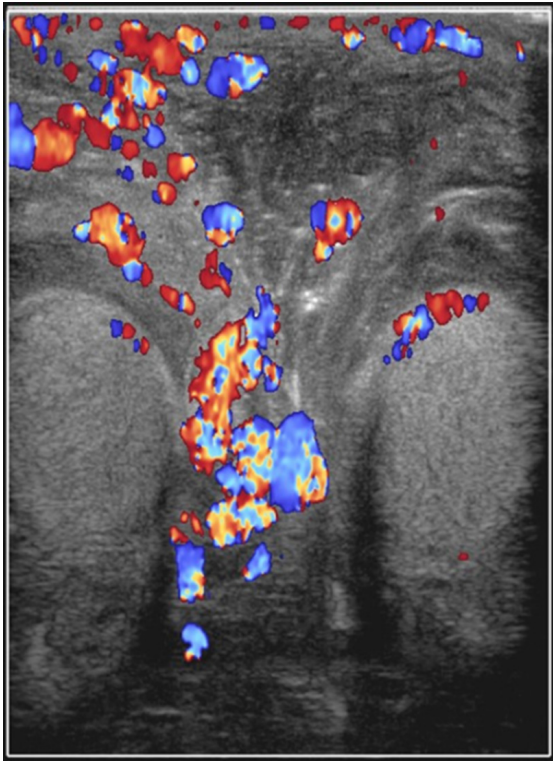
41-year-old man with scrotal AVM. Doppler ultrasound demonstrates abnormally increased flow through the right scrotal vasculature.
